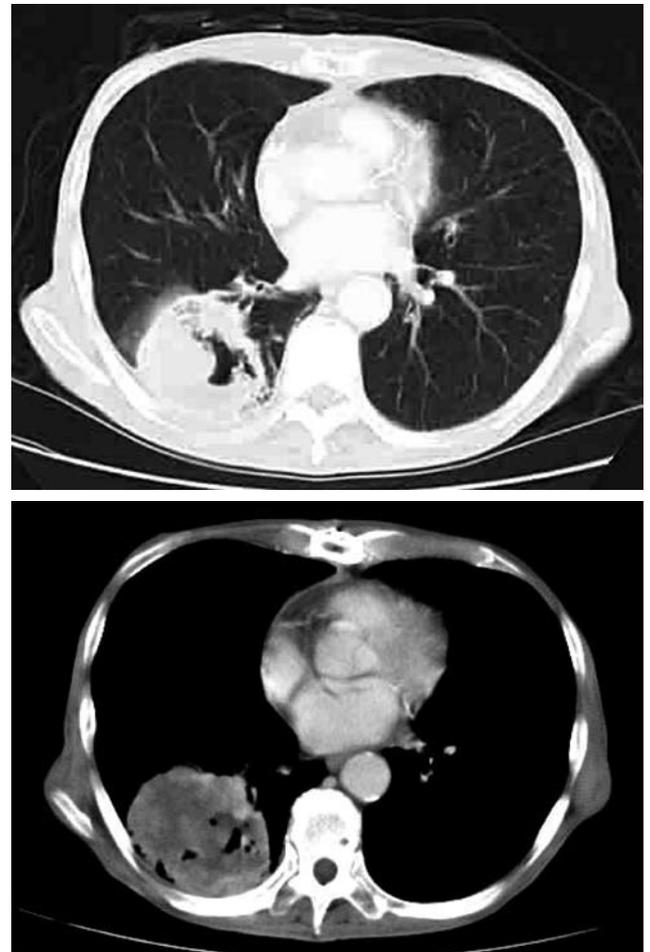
Chest computed tomography demonstrated a well-defined tumor with a cavity in the right basal segment. A: lung window setting; B: mediastinal window setting
